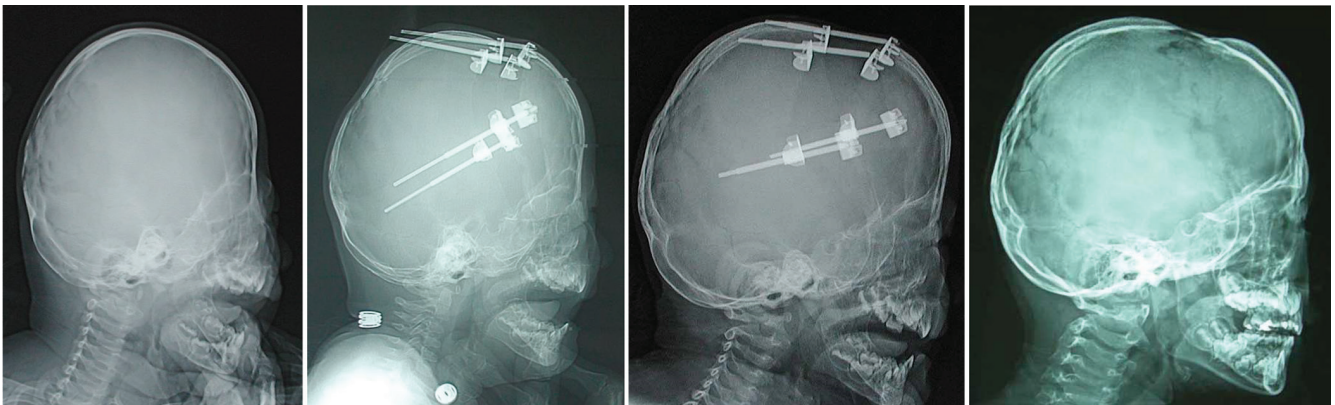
Representative case treated with distraction; A 8 month-old female with brachycephaly underwent a forehead advancement with gradual distraction. X-ray of pre-ope, during distraction, full expansion (2.3 cm anteriorly) and 10 years after (right to left in order).
